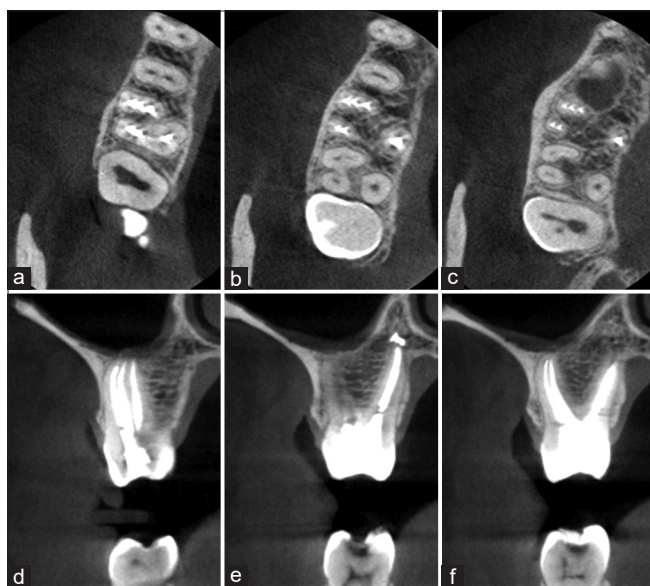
(a) Postoperative axial section cone-beam computed tomography (CBCT) image of tooth #3 at the cervical, (b) middle, and (c) apical level showing three roots and six root canals. (d) Postoperative coronal section CBCT image of tooth #3 showing adequately filled three root canals in the mesiobuccal root, (e) one root canal in the palatal root, and (f) two root canals in the distobuccal root and one root canal in the palatal root
